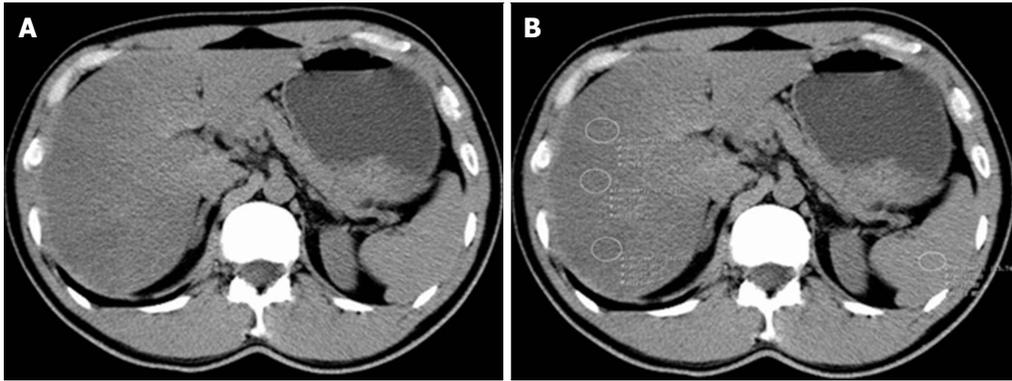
Computed tomography evaluation of fatty liver using a liver-to-spleen attenuation difference with unenhanced computed tomography. A: Diffuse fatty infiltration of liver with attenuation much lower than the spleen on visual analysis; B: Multiple regions-of-interest (white circles, ROIs) show mean hepatic attenuation (25 HU) and splenic attenuation (51 HU) with -26 HU liver-to-spleen attenuation difference, pointing to moderate-to-severe hepatosteatorosis.
